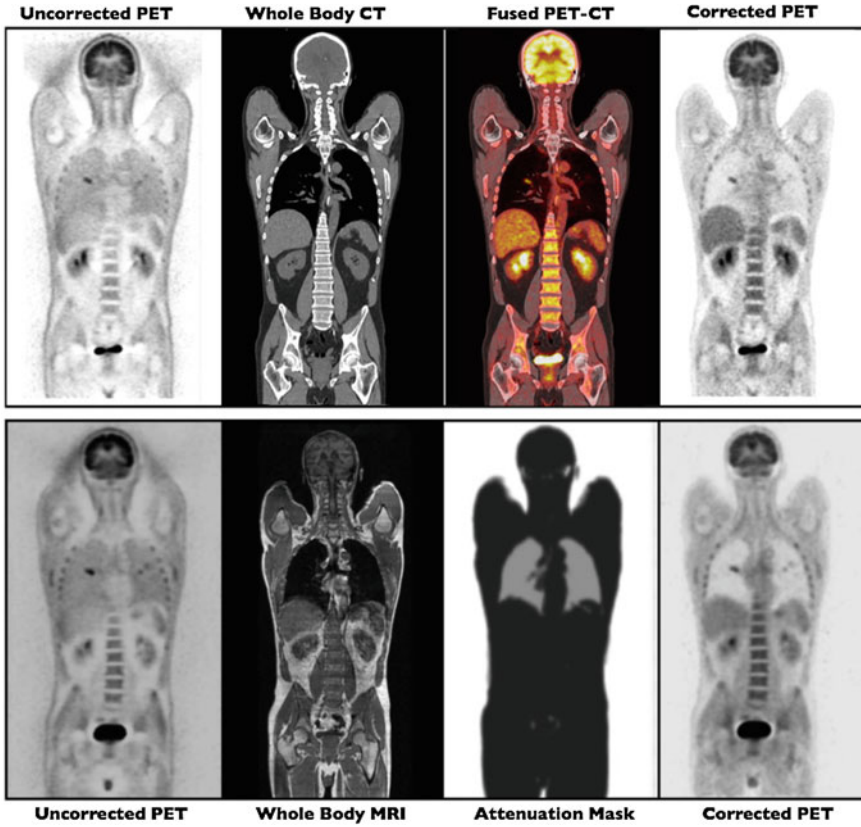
Comparison of CT-guided PET attenuation correction (*upper row*), and MR-guided PET attenuation correction (*lower row*), obtained in the same patient, where the two hybrid studies were acquired sequentially
